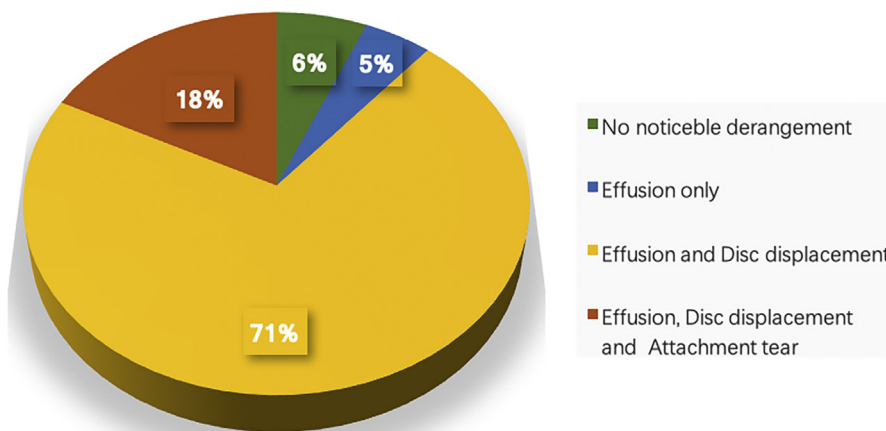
Severity of soft tissue injury as seen on magnetic resonance imaging studies.
